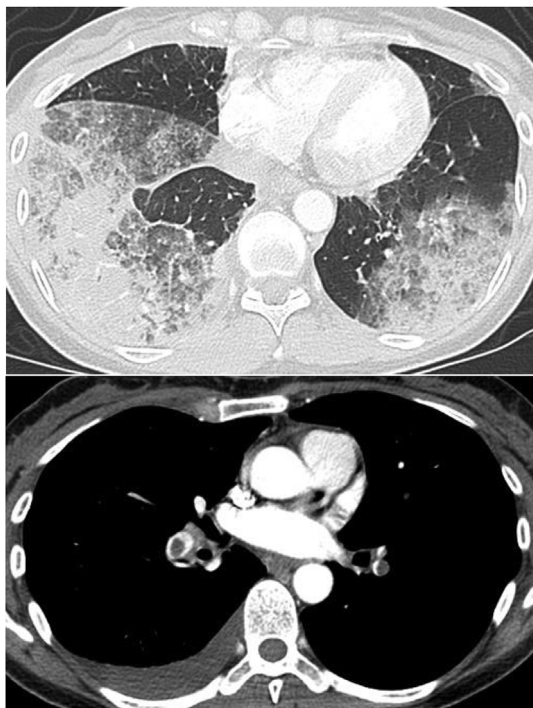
Chest contrast-enhanced computed tomography on hospital day 2 demonstrates wedge-shaped consolidation and ground-glass opacity in both lungs and emboli in both pulmonary arteries. There is a thrombus partially occluding the left popliteal vein.
